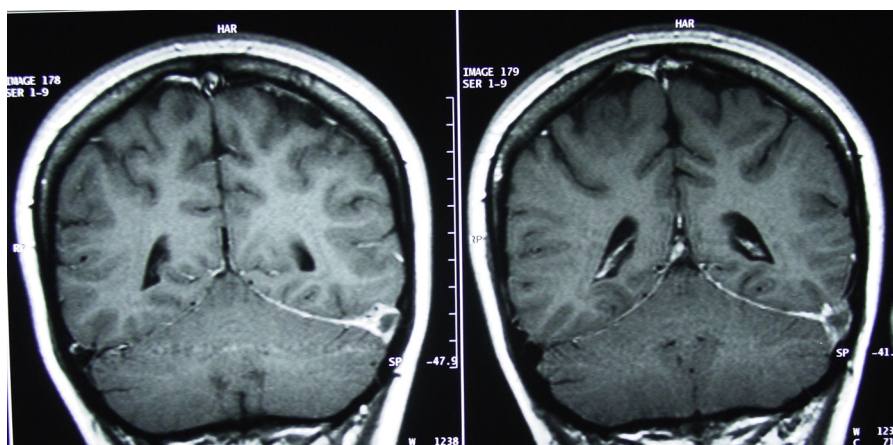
Cranial magnetic resonance imaging (MRI). Coronal T1 weighted image. Thrombus density caused central filling defect within left sigmoid sinus.
